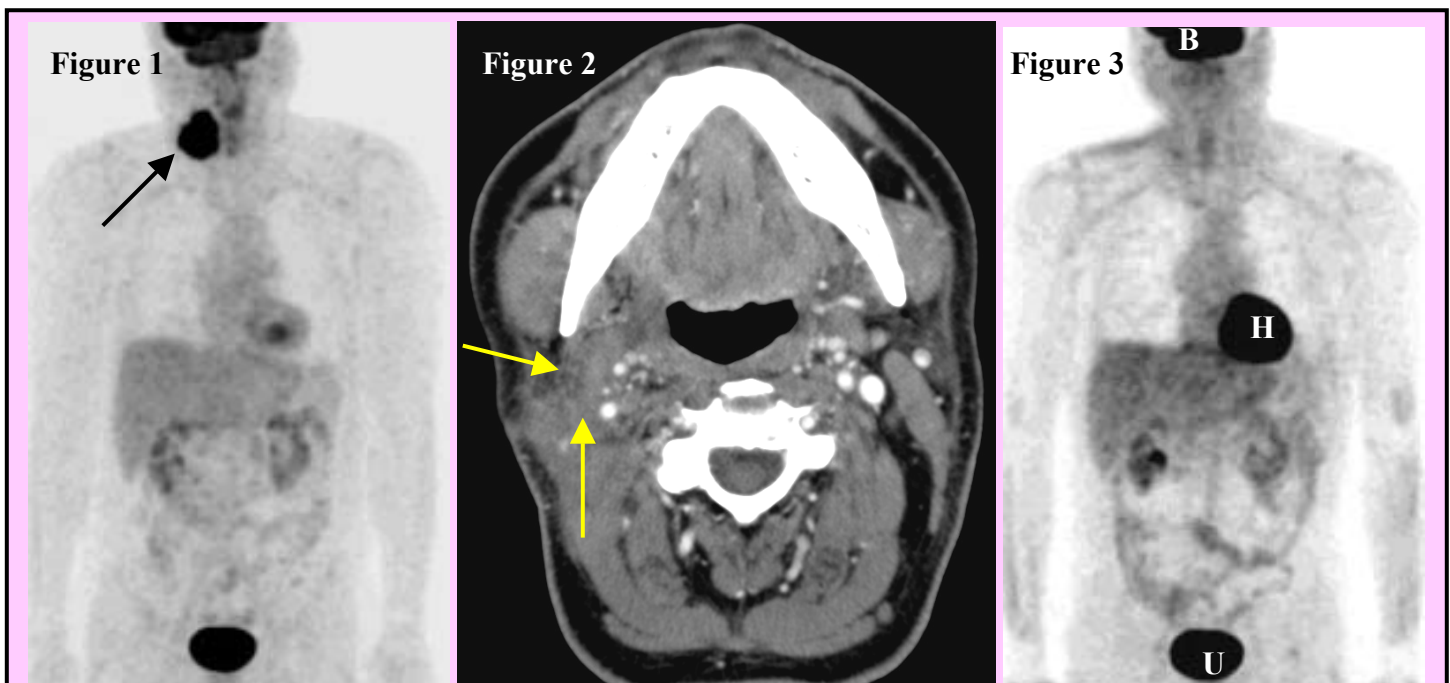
Pre-operative PET scan shows right neck mass (arrow) Figure 2: Post-contrast post-operative neck CT shows soft tissue prominence at the surgical site (arrows) Figure 3: Post-operative PET scan shows no abnormal activity at the surgical site (Normal physiological activity is seen in the brain [B], heart [H], and urinary bladder [U])
